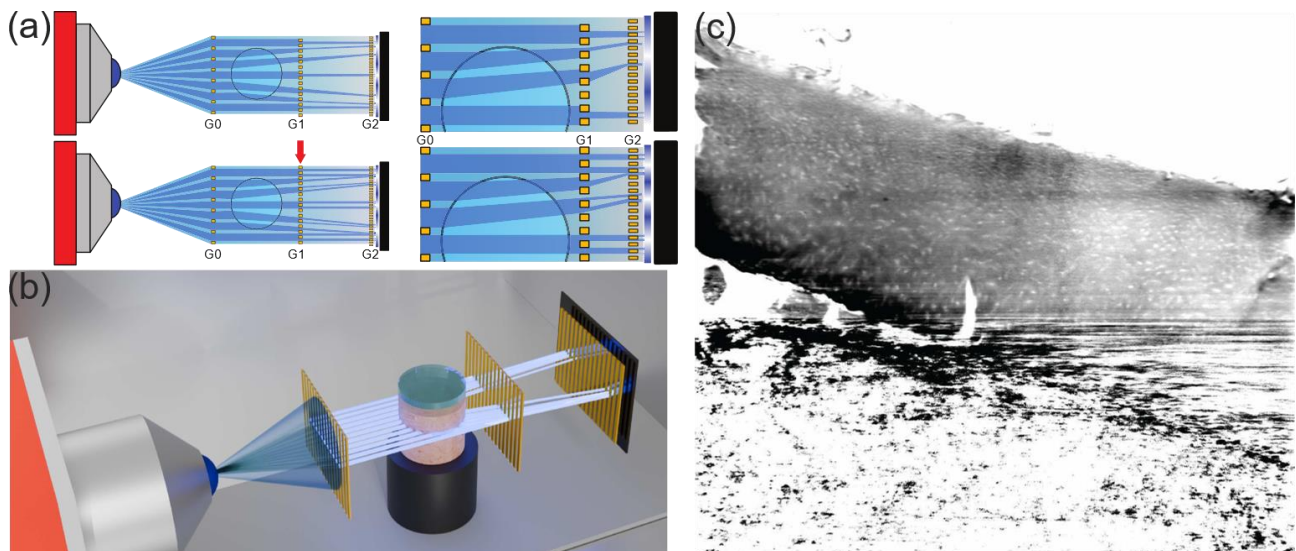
(a) Scheme of GI, in Talbot-Lau configuration. Provided the spatial coherence of the X-ray beam, only the sample gratings G1 and the detector gratings G2 are required. Otherwise, source gratings G0 are required, as in the depicted case. The distance of the detector gratings is determined according to the occurrence of the Talbot self-image
